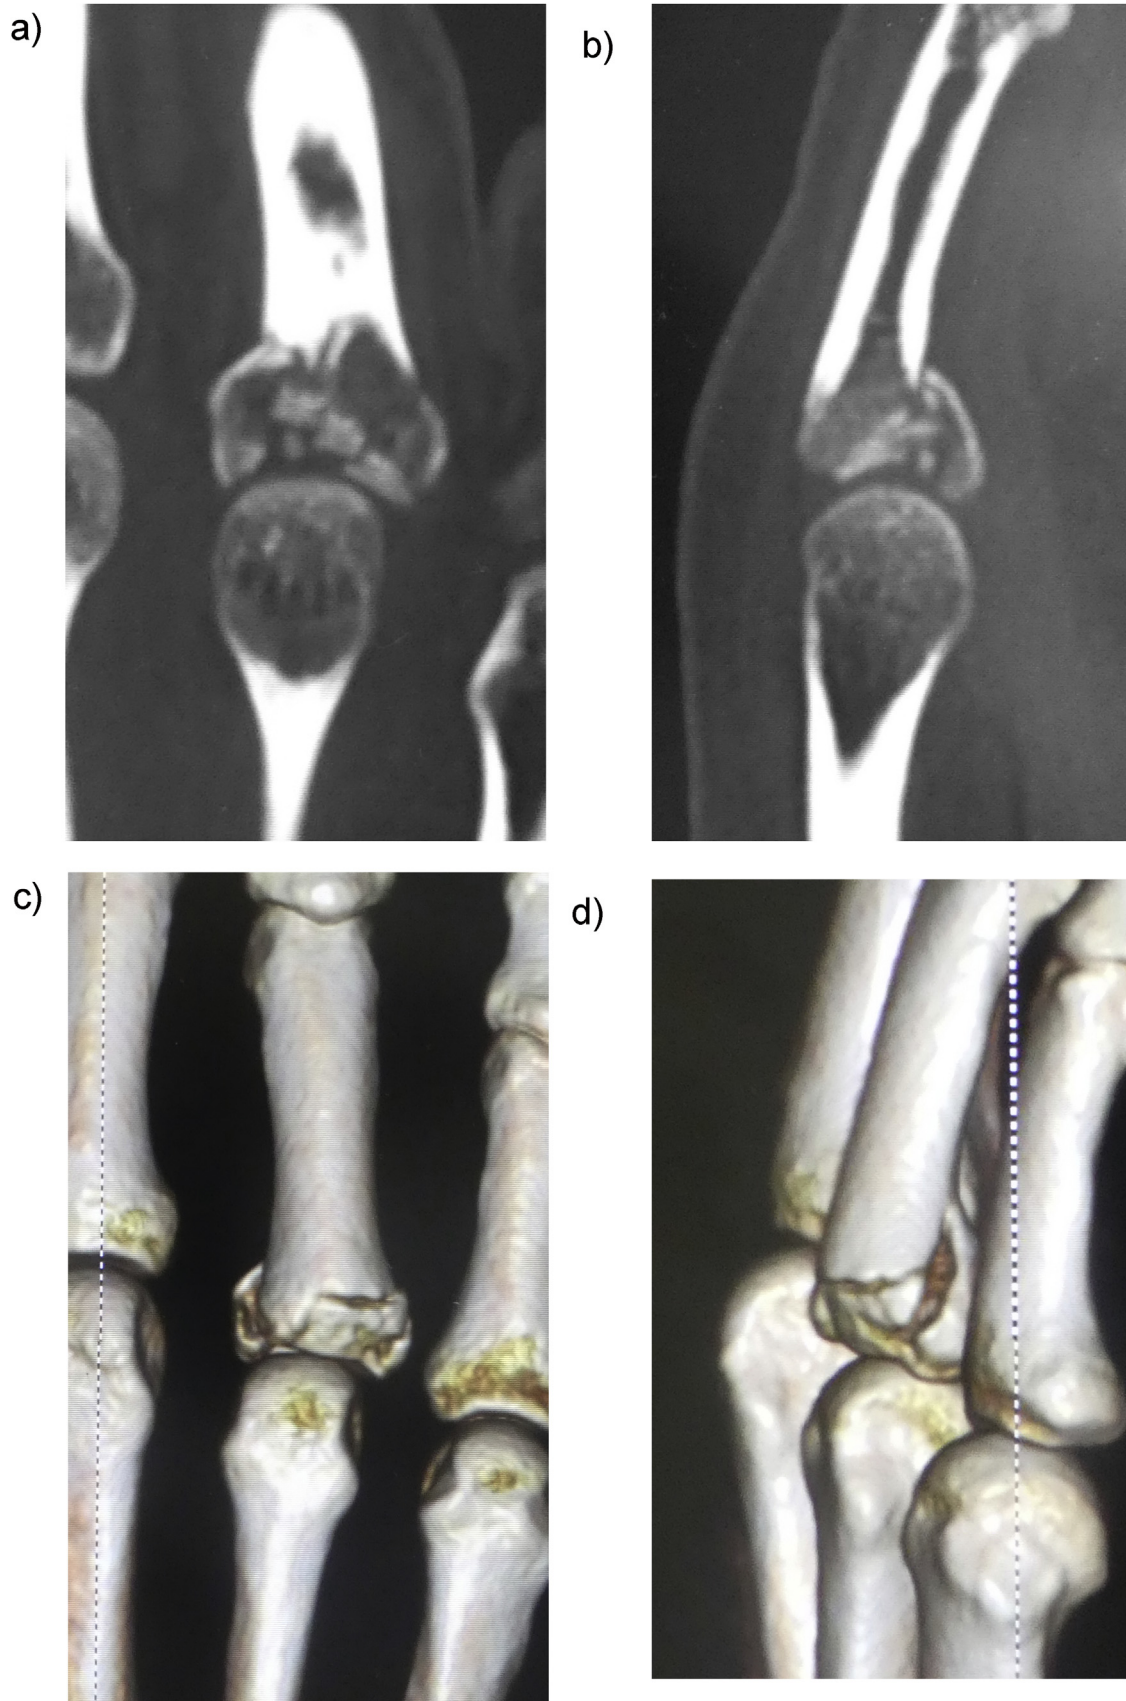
Plain computed tomographic and three-dimensional computed tomographic images showing a comminuted intraarticular fracture with central depression; A) coronal view, B) sagittal view, C) and D) three-dimensional computed tomographic images.
